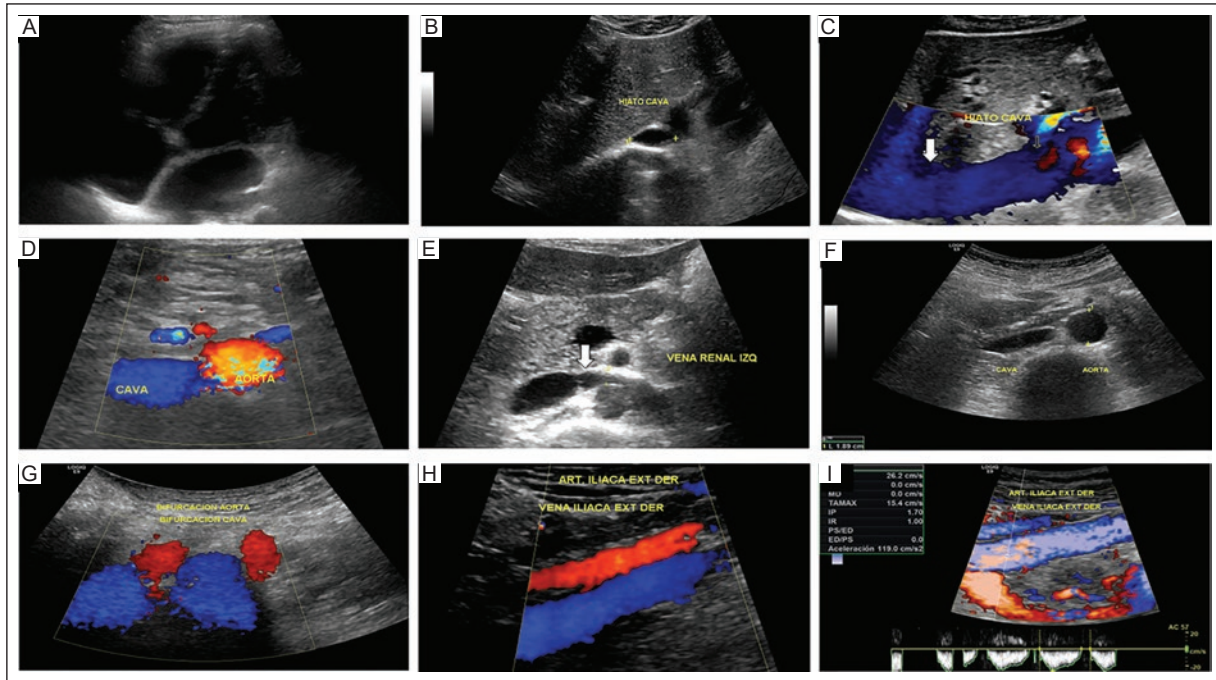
A: grayscale US subxiphoid approach showing the four chambers of the heart. B: transverse view, grayscale US showing the vena cava hiatus (3.54 cm, not shown). C: sagittal view, color Doppler US of the vena cava hiatus (arrow) to the root of the IVC (right atrium). D: transverse view, color doppler US showing normal aorta, IVC, superior mesenteric artery, and vein. E: transverse view, grayscale US showing the normal left renal vein (5 mm, not shown) at the junction of the aorta and superior mesenteric artery (arrow) and its junction with the normal IVC. F: transverse view, grayscale US of the normal aorta (1.89 cm) and IVC. G: transverse view, color Doppler US showing the bifurcation of the aorta and the IVC with normal patency and flow direction. H: sagittal view, color Doppler US of the right external iliac artery and vein showing normal patency and flow direction. I: sagittal view, color Doppler US and spectrum of the right external iliac vein with normal spectral morphology and velocity (26.2 cm/sec).
